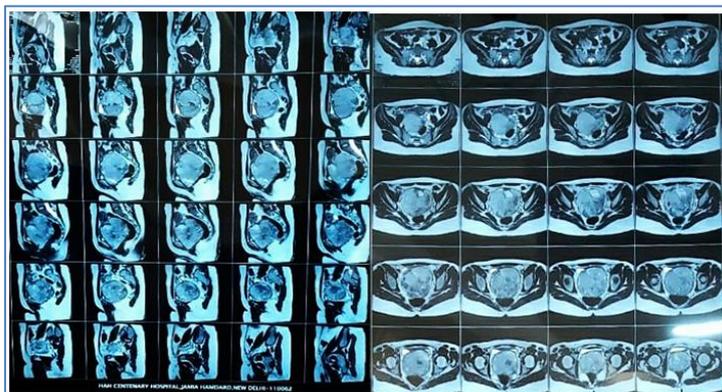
Abdominopelvic MRI scans showing a large cervical mass exerting pressure on the bladder and rectum
